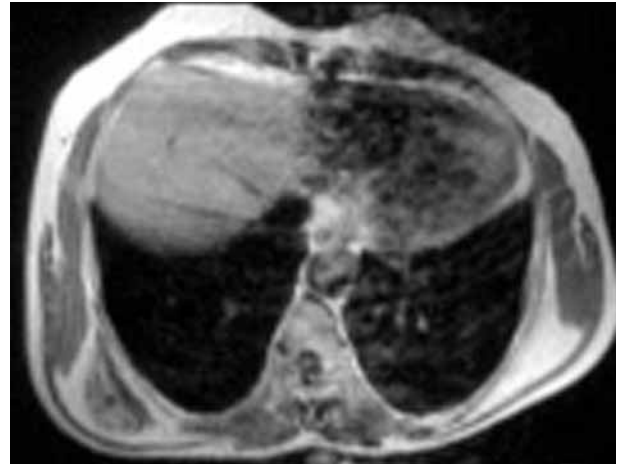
Axial MRI : T1-weighted image demonstrates the presence of different tissue components within the lesion : alternated plan of fat-like and fibrous-like tissue giving the lesion a multi layered pattern.
